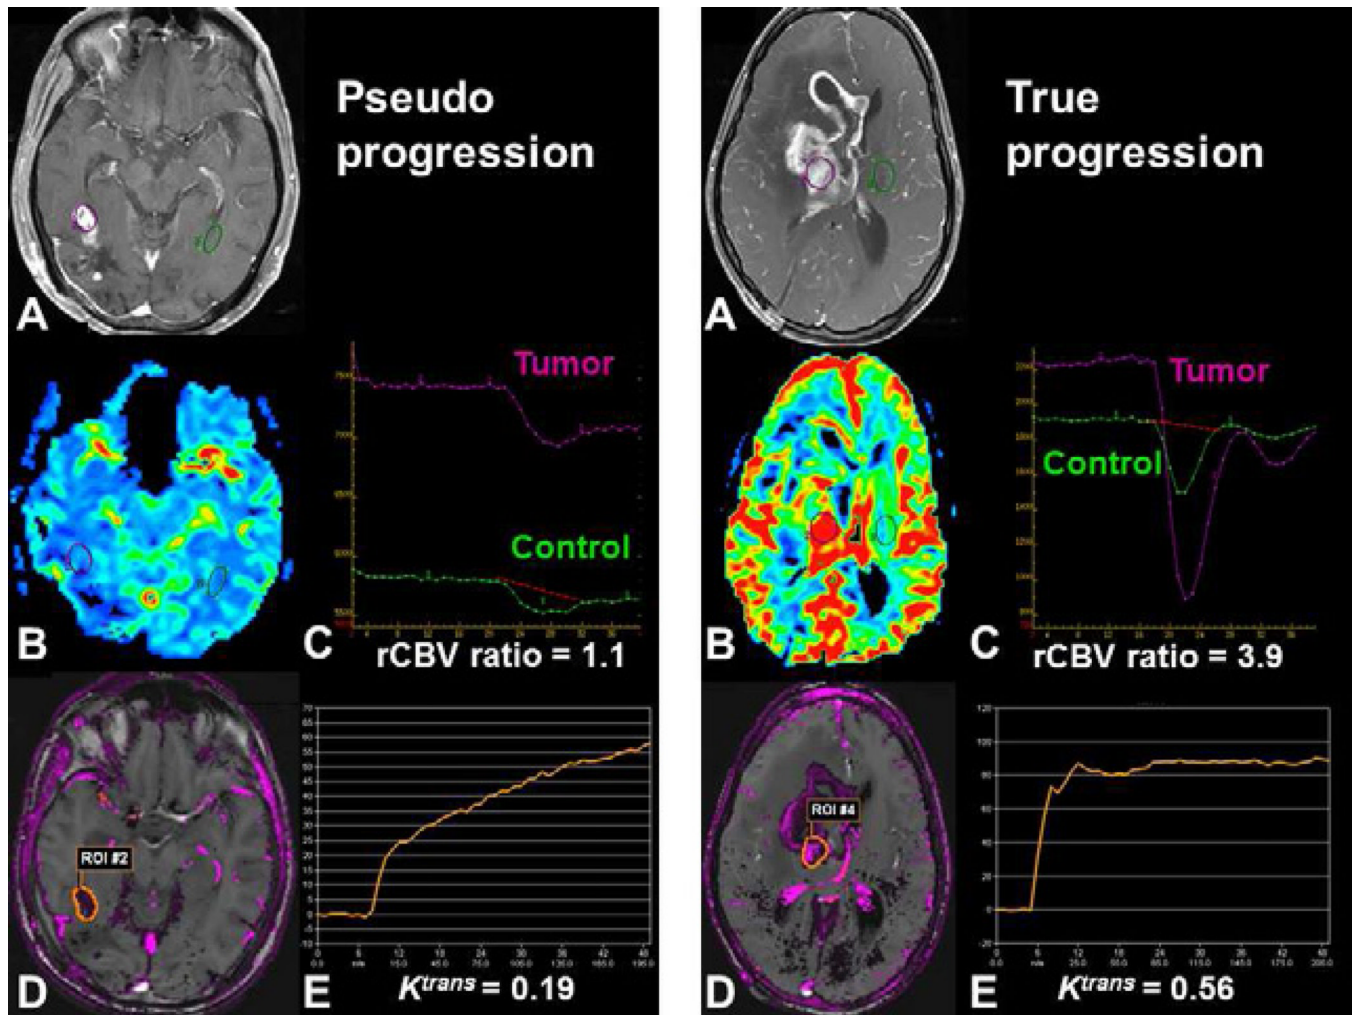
Post-therapeutic evaluation of high-grade glioma using DSC-MRI and DCE-MRI. Both patients demonstrate increased contrast enhancement 3 months following combined chemoradiotherapy with temozolomide. (A, F). Pseudoprogession may demonstrate decreased perfusion with a low rCBV ratio using DSC-MRI (B, C) and moderate vascular permeability (D, E) with a progressive enhancement (E) using DCE-MRI. True early progression may demonstrate increased perfusion with a high rCBV ratio (G, H) with high permeability and rapid enhancement (I, J).
